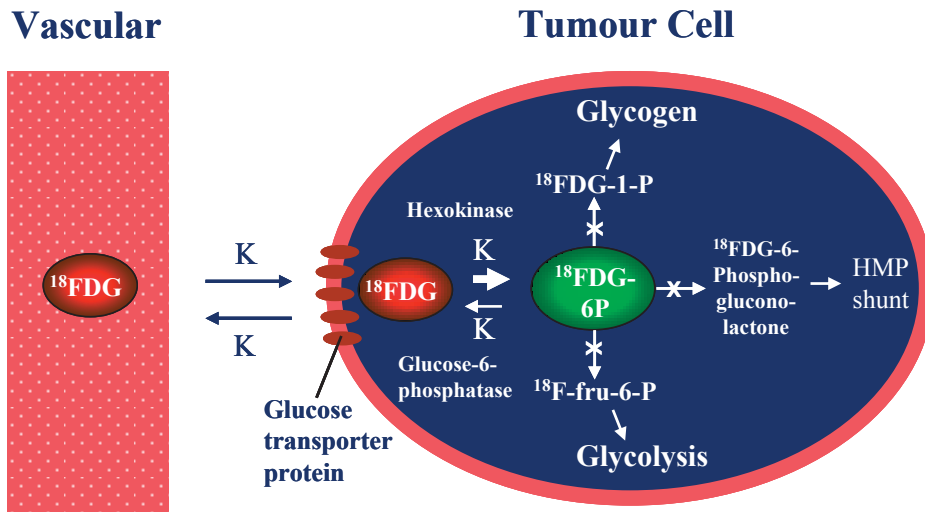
The uptake and accumulation of FDG in cells. Adapted from Heron et al.⁷⁴
